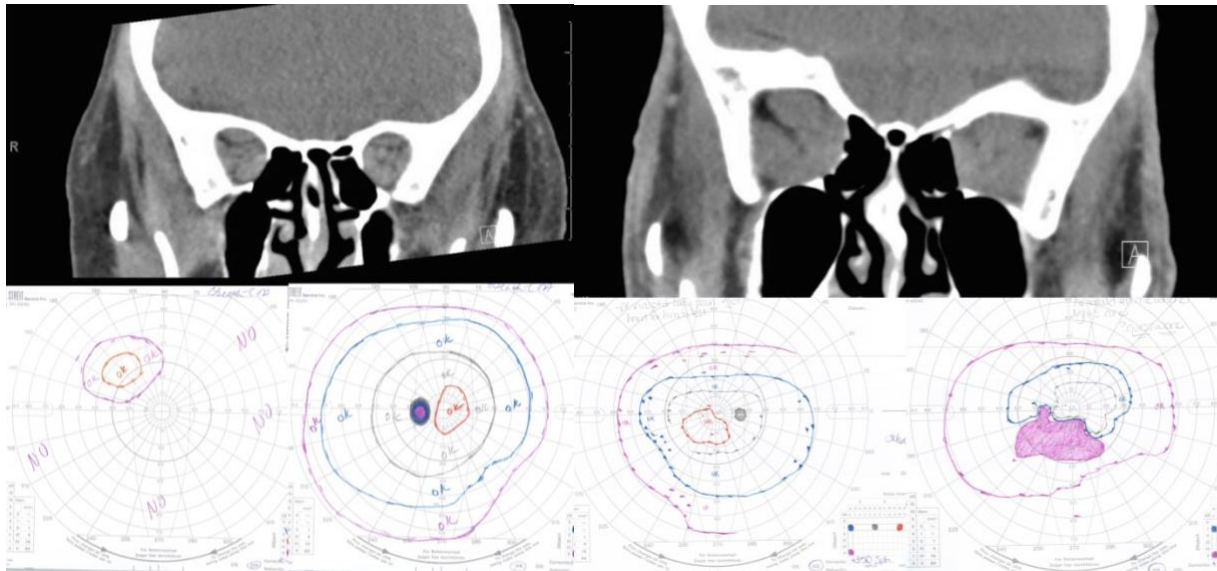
Compressive optic neuropathy. This sequence shows a series of CT scans from patients with compressive optic neuropathy, with their associated visual fields.
